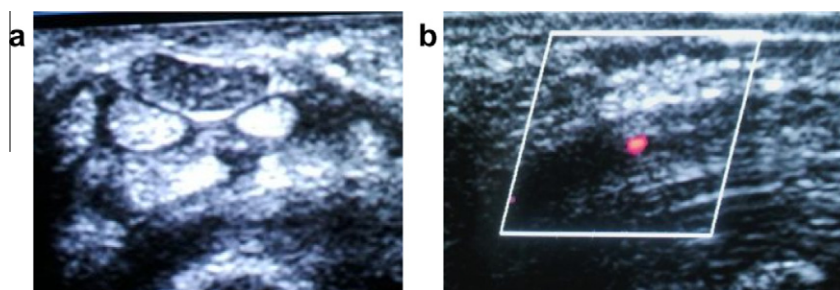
(a) Transverse image of carpal tunnel revealed absent gray scale signs of CTS with normal median nerve CSA (10 mm^2), absent edema and absent bowing of the flexor retinaculum. (b) Power Doppler revealed +ve sign of intraneural hypervascularization.
